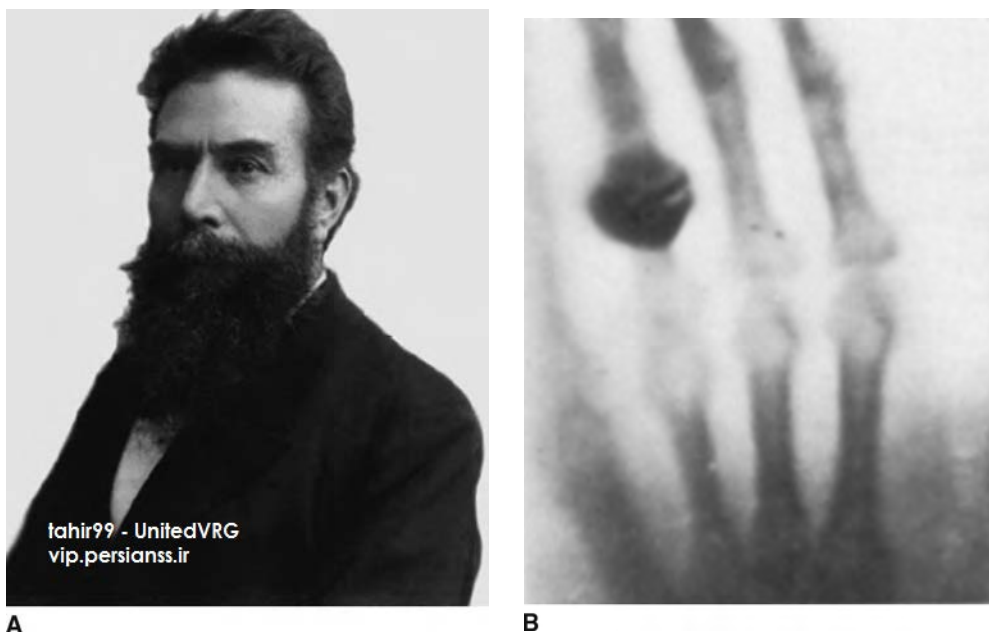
Wilhelm Conrad Roentgen (1845–1923) in 1896 (A). Roentgen received the first Nobel Prize in Physics in 1901 for his discovery of x-rays on November 8, 1895. The beginning of diagnostic radiology is represented by this famous radiographic image, made by Roentgen on December 22, 1895 of his wife's hand (B). The bones of her hand as well as two rings on her finger are clearly visible. Within a few months, Roentgen had determined the basic physical properties of x-rays. Roentgen published his findings in a preliminary report entitled "On a New Kind of Rays" on December 28, 1895 in the Proceedings of the Physico-Medical Society of Wurzburg. An English translation was published in the journal *Nature* on January 23, 1896. Almost simultaneously, as word of the discovery spread around the world, medical applications of this "new kind of ray" rapidly made radiological imaging an essential component of medical care. In keeping with mathematical conventions, Roentgen assigned the letter "x" to represent the unknown nature of the ray and thus the term "x-rays" was born.
